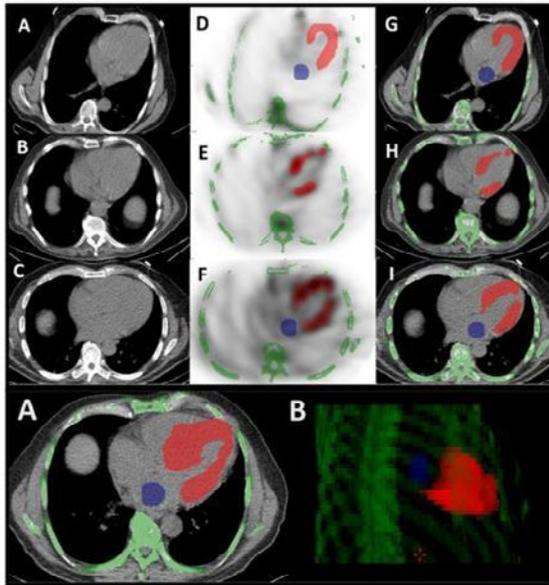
Visual examples and VOI methodology on quantitative ^{99m}Tc -PYP SPECT/CT.
